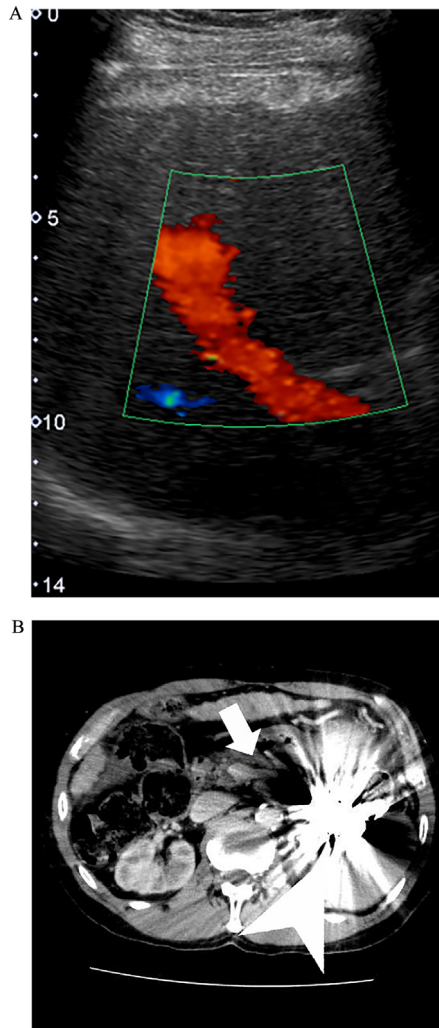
(A) Doppler ultrasonography shows hepatopetal flow in the portal vein (red signals). (B) Abdominal contrast-enhanced computed tomography (CT) of the abdomen. The splenic vein is narrowed compared to preoperative CT (Fig. 1A; arrow). Coil artifact in the splenorenal (SR) shunt is observed (arrowhead).
